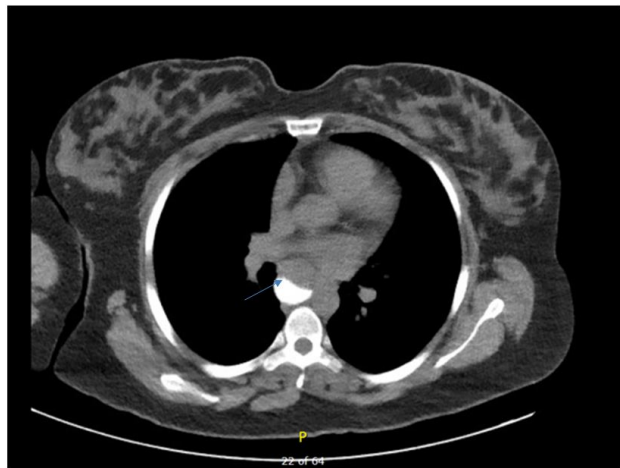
CT chest showing sub carinal periesophageal mass.
